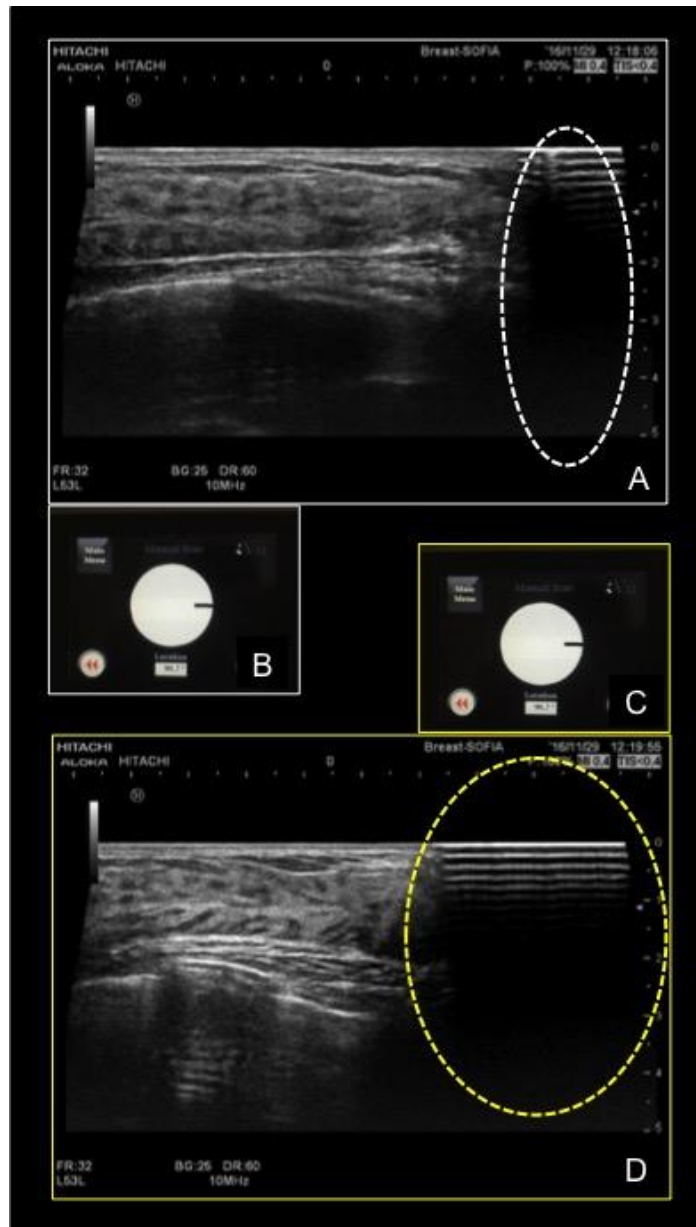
F, 50 yo. the figure shows the case missed at 3D automated breast ultrasonography due to the position of the lesion.
